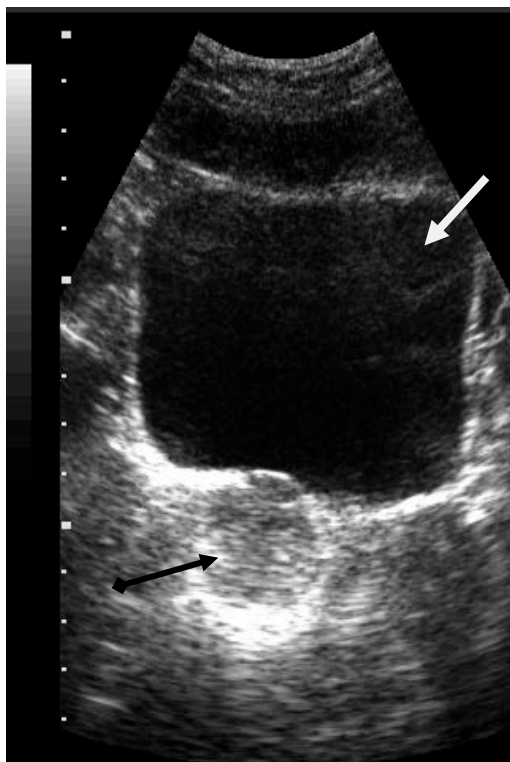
Ultrasound scan of the urinary bladder. Transverse scan. Urinary bladder (arrow). Prostate (arrow with a rhombus). Norm
